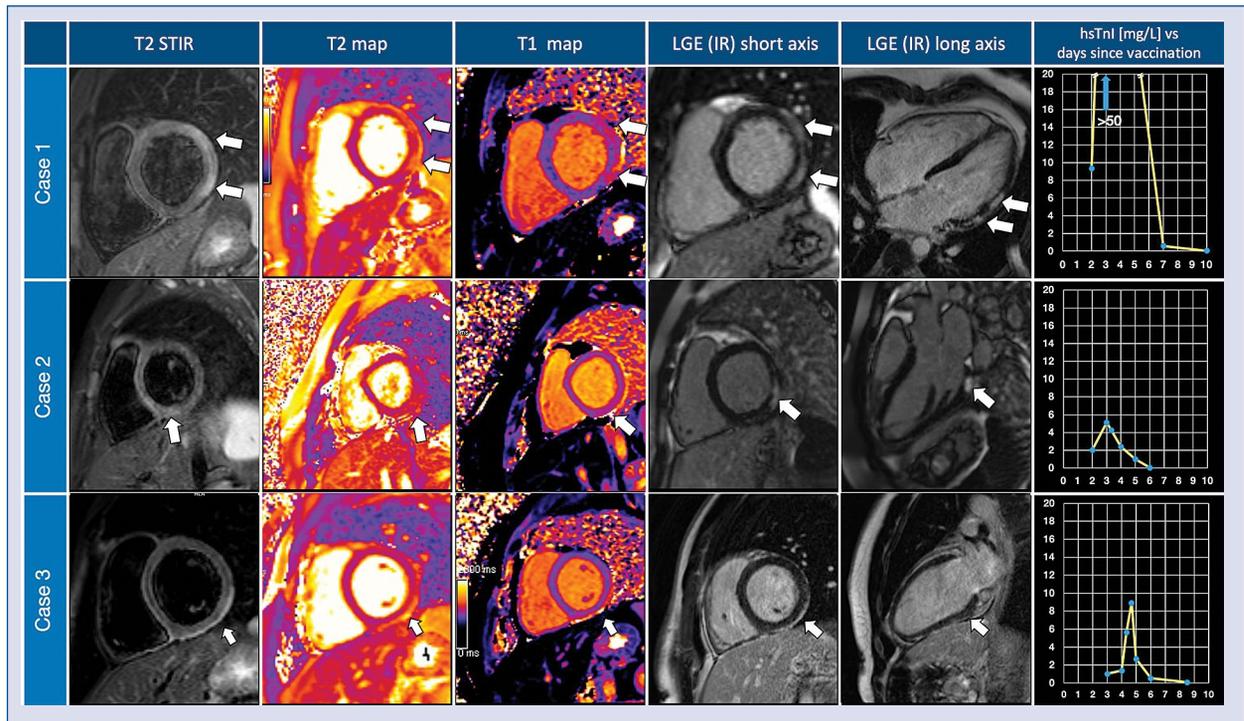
Case 1. Subepicardial hyperintensity consistent with edema (i.e., features of acute injury) in the basal inferior, infero-lateral and antero-lateral segments in the T2-weighted short tau inversion recovery (STIR) image, paralleled by increased T2 and T1 relaxation times in parametric mapping and a matching late gadolinium enhancement (LGE) area suggestive of irreversible damage (arrows); Case 2. Mild localized edema found in the basal inferior and infero-lateral segments in the T2 STIR image, again paralleled by increased T2 and T1 relaxation times and a small LGE patch found solely in the basal infero-lateral segment (arrows); Case 3. Mild subepicardial edema in T2 STIR closely matched by T1 and T2 increase in parametric mapping, as well as subtle subepicardial LGE in the basal inferior and infero-lateral segments (arrows); IR — inversion recovery; hsTnI — high sensitivity troponin I plasma levels by days since vaccination.
